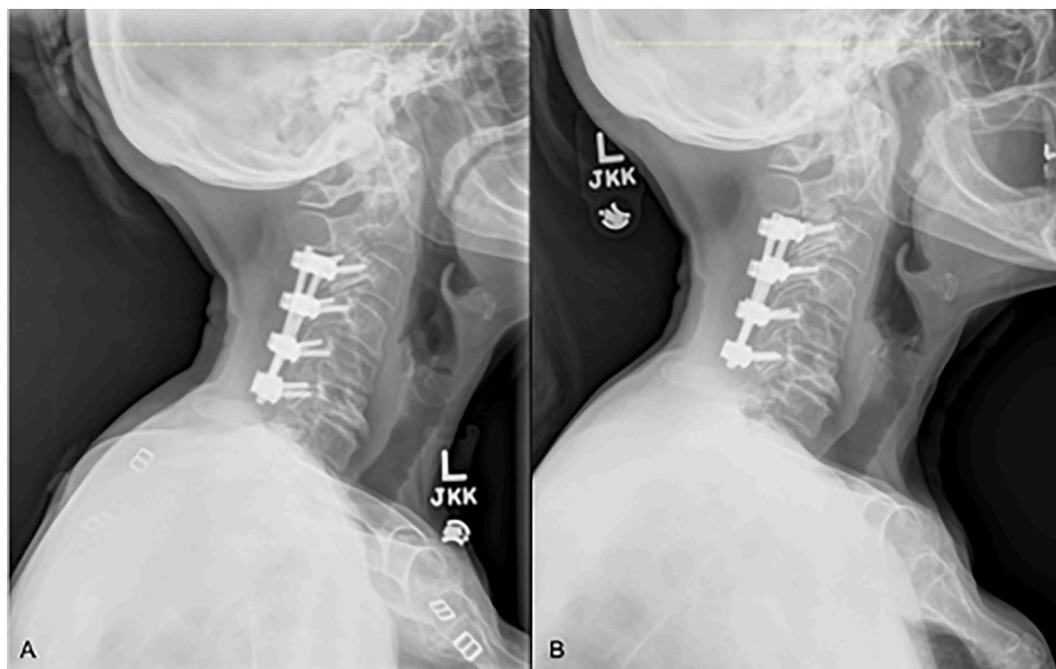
A/B: Pre-operative X-Ray of historical C3-C6 posterior spinal fusion.
